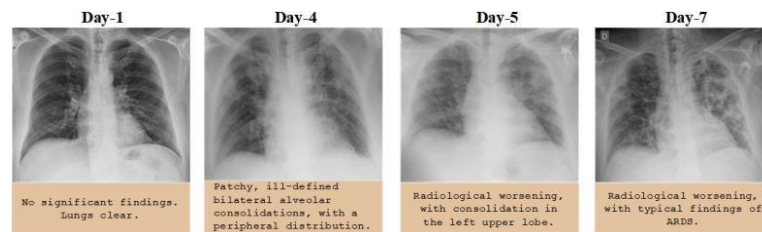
Chest X-ray images of a 50-year-old COVID-19 patient with pneumonia over a week
